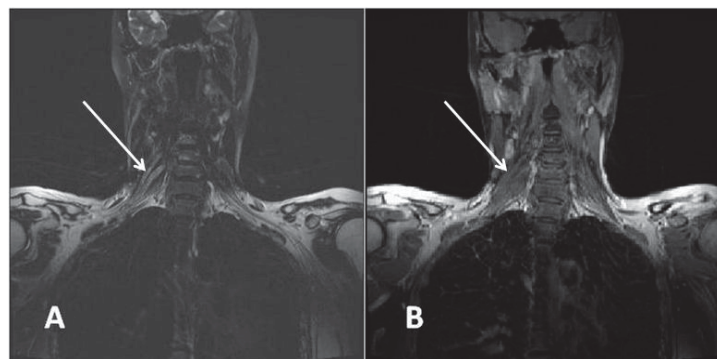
T2 FS sequence magnetic resonance imaging (MRI) shows increased signal intensity in both C7 roots in patient with multifocal motor neuropathy (the patient No 2).
